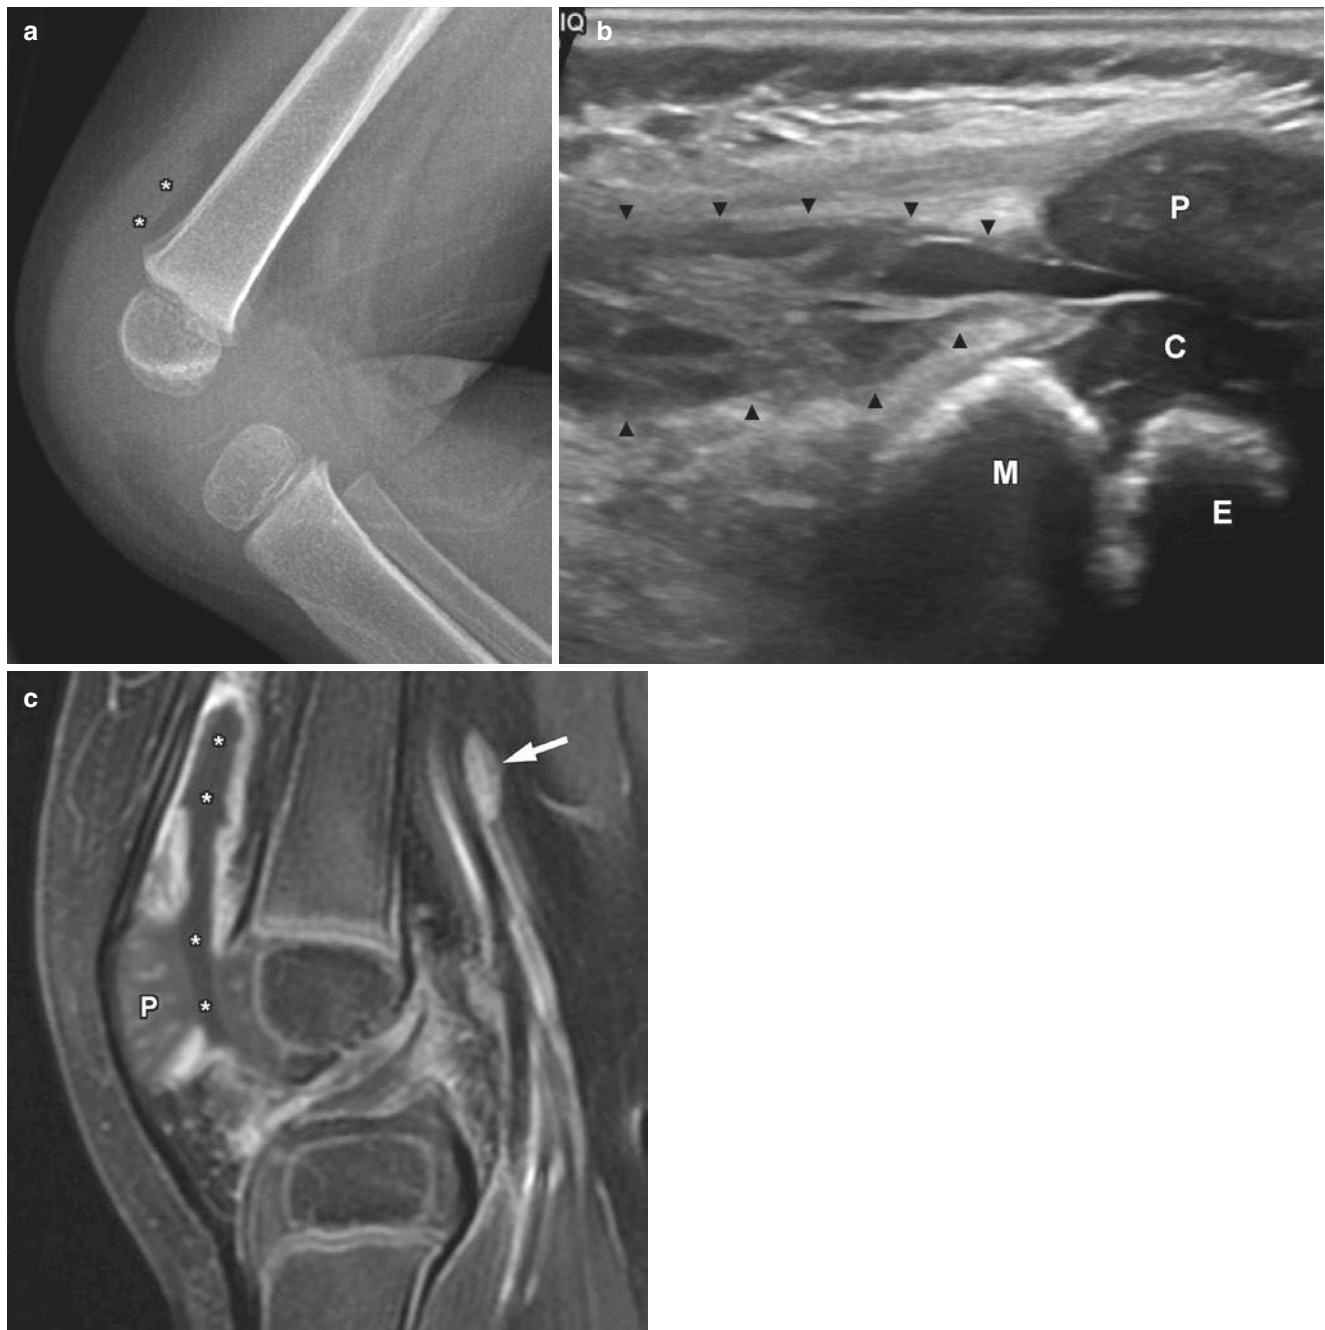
Nineteen month-old girl with oligoarticular juvenile idiopathic arthritis. The girl presented with knee swelling and refusal to bear weight. (a) Lateral radiograph shows a knee joint effusion (*asterisks*). Diffuse periarticular soft tissue swelling is seen, most notable in the infrapatellar region. (b) Sagittal ultrasound shows a complex effusion within the suprapatellar pouch (*arrowheads*) with debris, septations and synovial thickening. *P* patella, *M* distal femoral metaphysis, *E* distal
